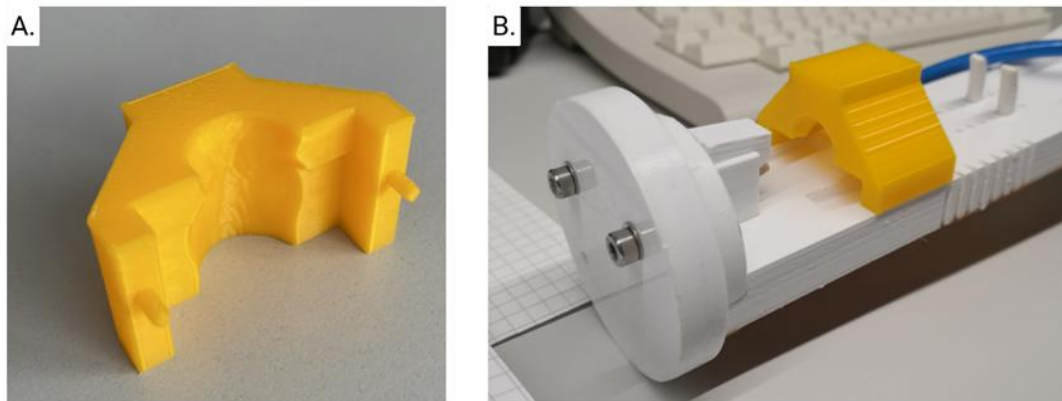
Production of the anatomical collar. A) Example of anatomical collar and B) anatomical collar fixed on SIRMIO μ CT bed.
